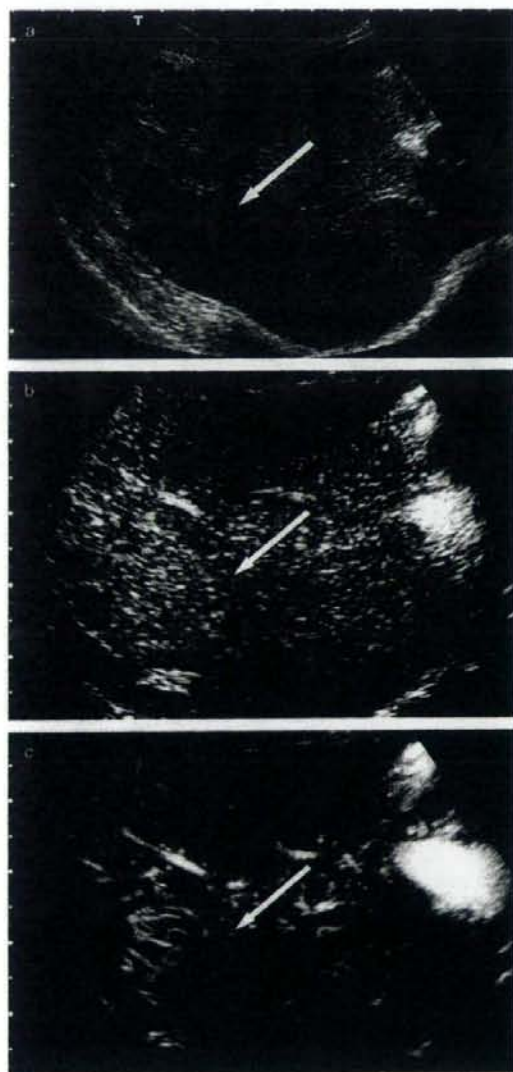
A 78-year-old man with a 30-mm-diameter, moderately-differentiated hepatocellular carcinoma (HCC) in the right lobe of his liver. (a) Baseline ultrasound image shows a focal hypoechoic HCC (arrow) in the right hepatic lobe. (b) Conventional harmonic image obtained during the portal venous phase—that is, 50 s after injection of the microbubble contrast agent—shows HCC (arrow) with homogeneous enhancement relative to the adjacent liver. (c) Microflow image obtained during the portal venous phase—that is, 55 s after injection of the microbubble contrast agent—shows the blood vessel architecture more distinctly than the conventional harmonic image. Border between the tumoral (arrow) and non-tumoral regions was distinct. Proliferation of tortuous and meandering blood vessels is clearly visible. Properties are characteristic of the vascular pattern.
